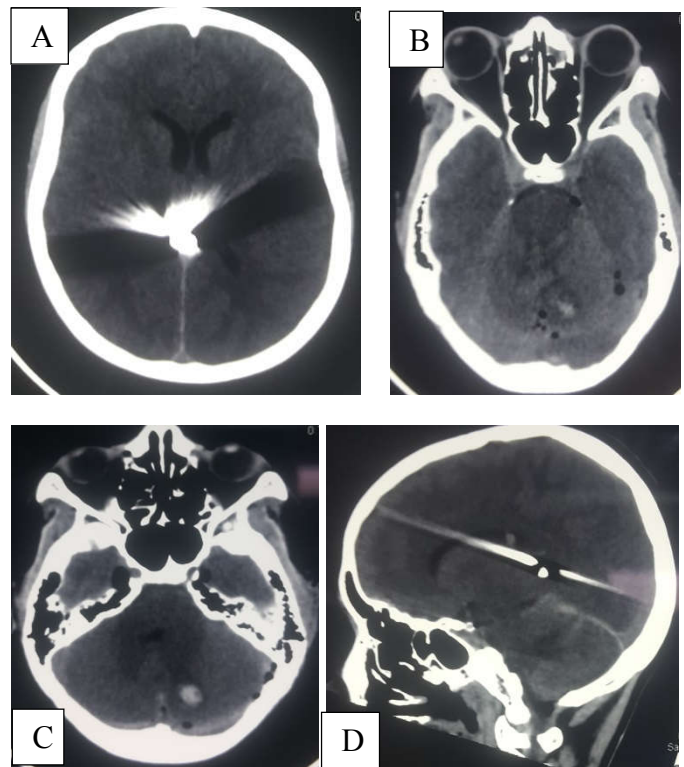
Axial CT brain without contrast the bullet in the midline; the bullet did not exit the intracranial cavity (A and D). A left sided intraparenchymal cerebellar hematoma is present with posterior fossa pneumocephalus (B and C). Diffuse sulcal effacement is appreciated in all images
